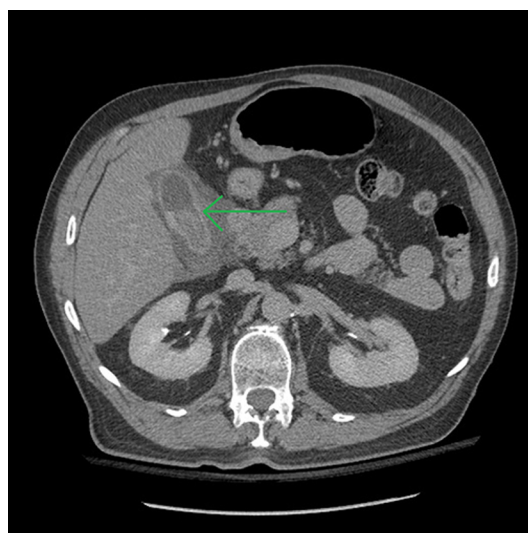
59-year-old male with perforation of the gallbladder. Findings: Axial contrast-enhanced CT image of the abdomen through the gallbladder in the delayed phase demonstrates increasing density within the gallbladder representing accumulating blood within the gallbladder. Technique: Axial CT image of the abdomen and pelvis with IV contrast performed in the delayed phase.
